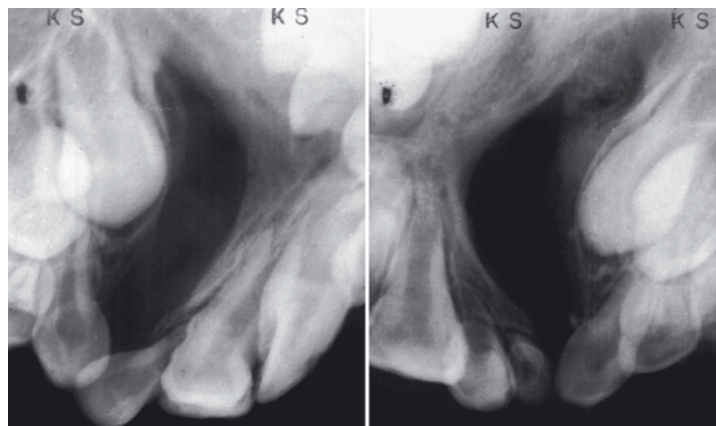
Radiograph of a premaxilla showing two central and one lateral incisors (*left*) and twined lateral incisors and one malformed central incisor (*right*)
